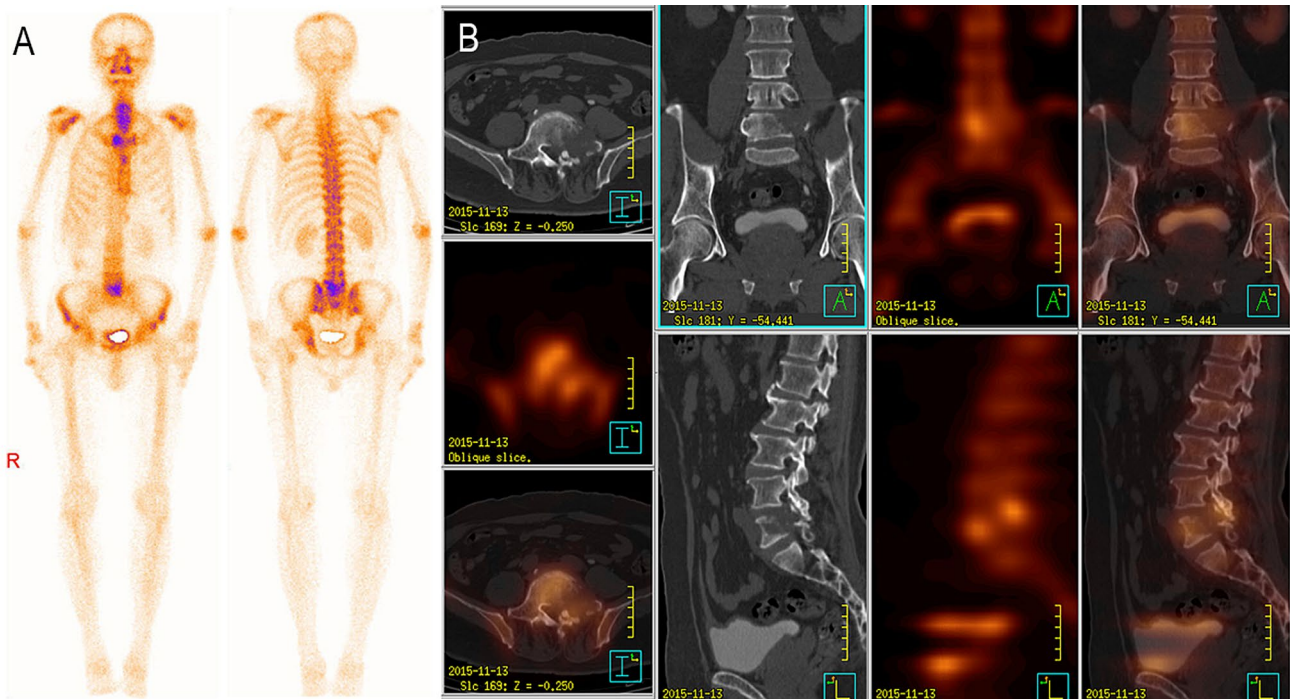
Male, 70 years old, 7 years after rectal cancer surgery, low back pain with left lower extremity pain without obvious cause for more than 1 month. Whole-body bone plane image shows abnormal radioactive concentration at the fifth lumbar spine (a). SPECT/CT image shows fifth lumbar vertebral body and left accessory osteolytic
